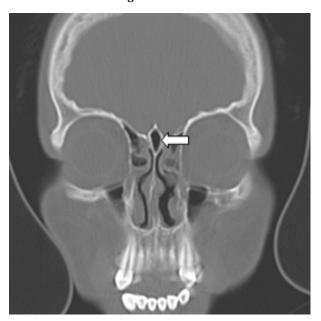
CT scan PNS coronal section showing pneumatisation of crista galli
